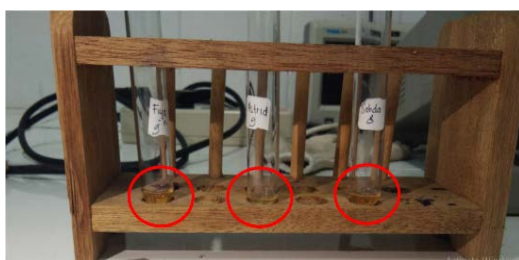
Blood serum prior to exposure to ultrasound Piezoelectric transducer (source: authors' own documentation)
